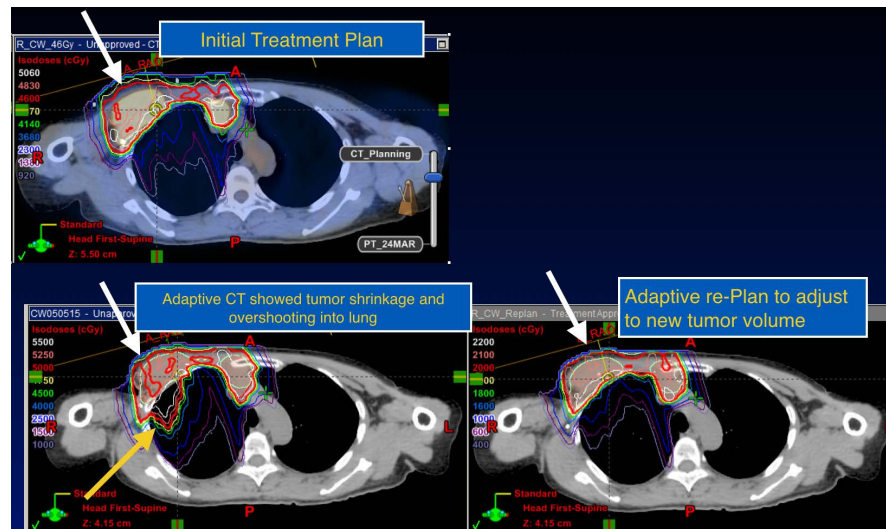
An adaptive CT scan at 4 weeks showed tumor shrinkage, which caused the dose to spill into the lung (yellow arrow). This was corrected with the replan to accommodate the new geometry. CT: computed tomography.
